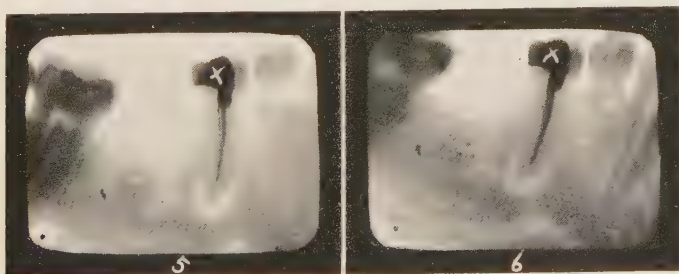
Case of Miss S. Radiograph No. 5, three months after filling the root canal. Radiograph No. 6, six months after filling the root canal.
